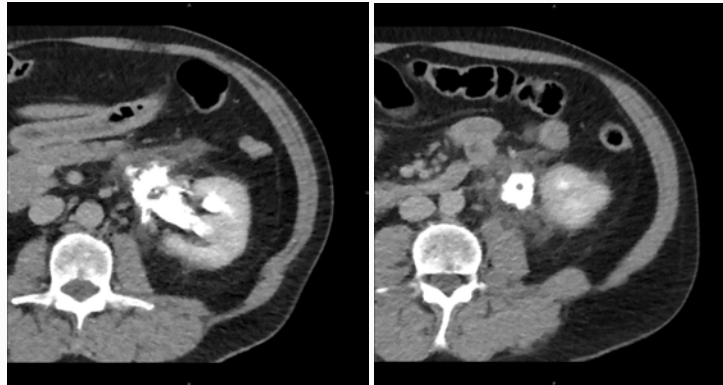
CT images showing initial extravasation of the contrast product (Arrows).
